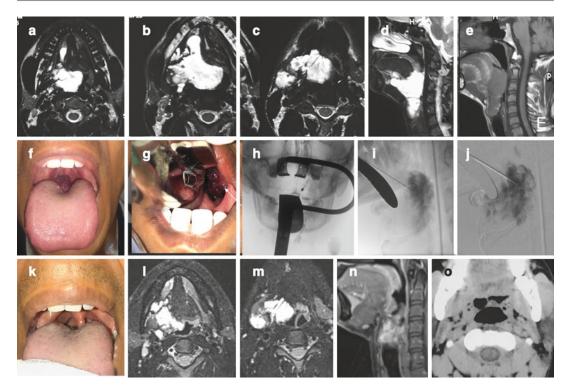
25 year old male presenting with swelling of right submandibular region, dysphagia and hoarseness of voice. On indirect laryngoscopy, purplish mass was seen in the posterior one-third of the tongue and laryngopharynx region. (a, b, c, d, e) Axial MRI images in STIR sequence show multilobulated trans-spatial venous malformation in the right paraglottic region and extending to the floor of the mouth. There is compression of the airway. Multiple phleboliths are seen as rounded signal voids. (e) Sagittal T1WI showing airway compression. (f) Clinical photograph showing bulge on the right posterior one-third of the tongue. Percutaneous sclerotherapy through the right submandibular region and permucosal injection was done transorally using spinal needle and mouth retraction
